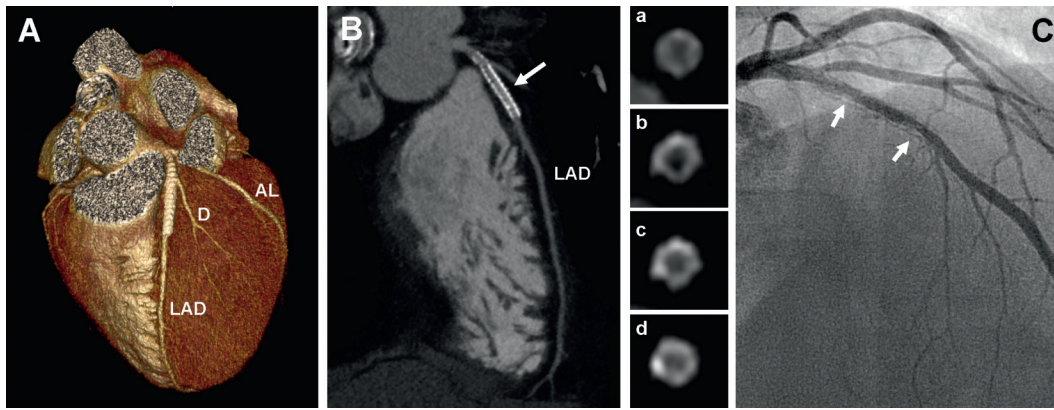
CTA of a 39-year-old man with prior PCI of the LAD revealing in-stent restenosis. Panel A shows a three-dimensional volume rendered reconstruction of the heart, giving an overview of the LAD, D1 and a large AL. A curved multiplanar reconstruction in Panel B shows two partially overlapping stents (Cypher 3.5 x 33 mm, Zeta 3.5 x 23 mm) in the proximal LAD (arrow) with severe in-stent hyperplasia. On the right hand side, four transverse sections of the stent indicate low-attenuating neointimal hyperplasia corresponding to non-calcified (transverse section b) and mixed-plaque (transverse section d). Transverse sections of the proximal (a) and mid stents sections (c) show a normal contrast-enhanced lumen. On ICA, the patient was diagnosed with in-stent neointimal proliferation (arrows) with severe lumen reduction of the distal stent. AL: anterolateral branch; D1: first diagonal branch; ICA: invasive coronary angiography; LAD: left anterior descending coronary artery; PCI: percutaneous coronary intervention
